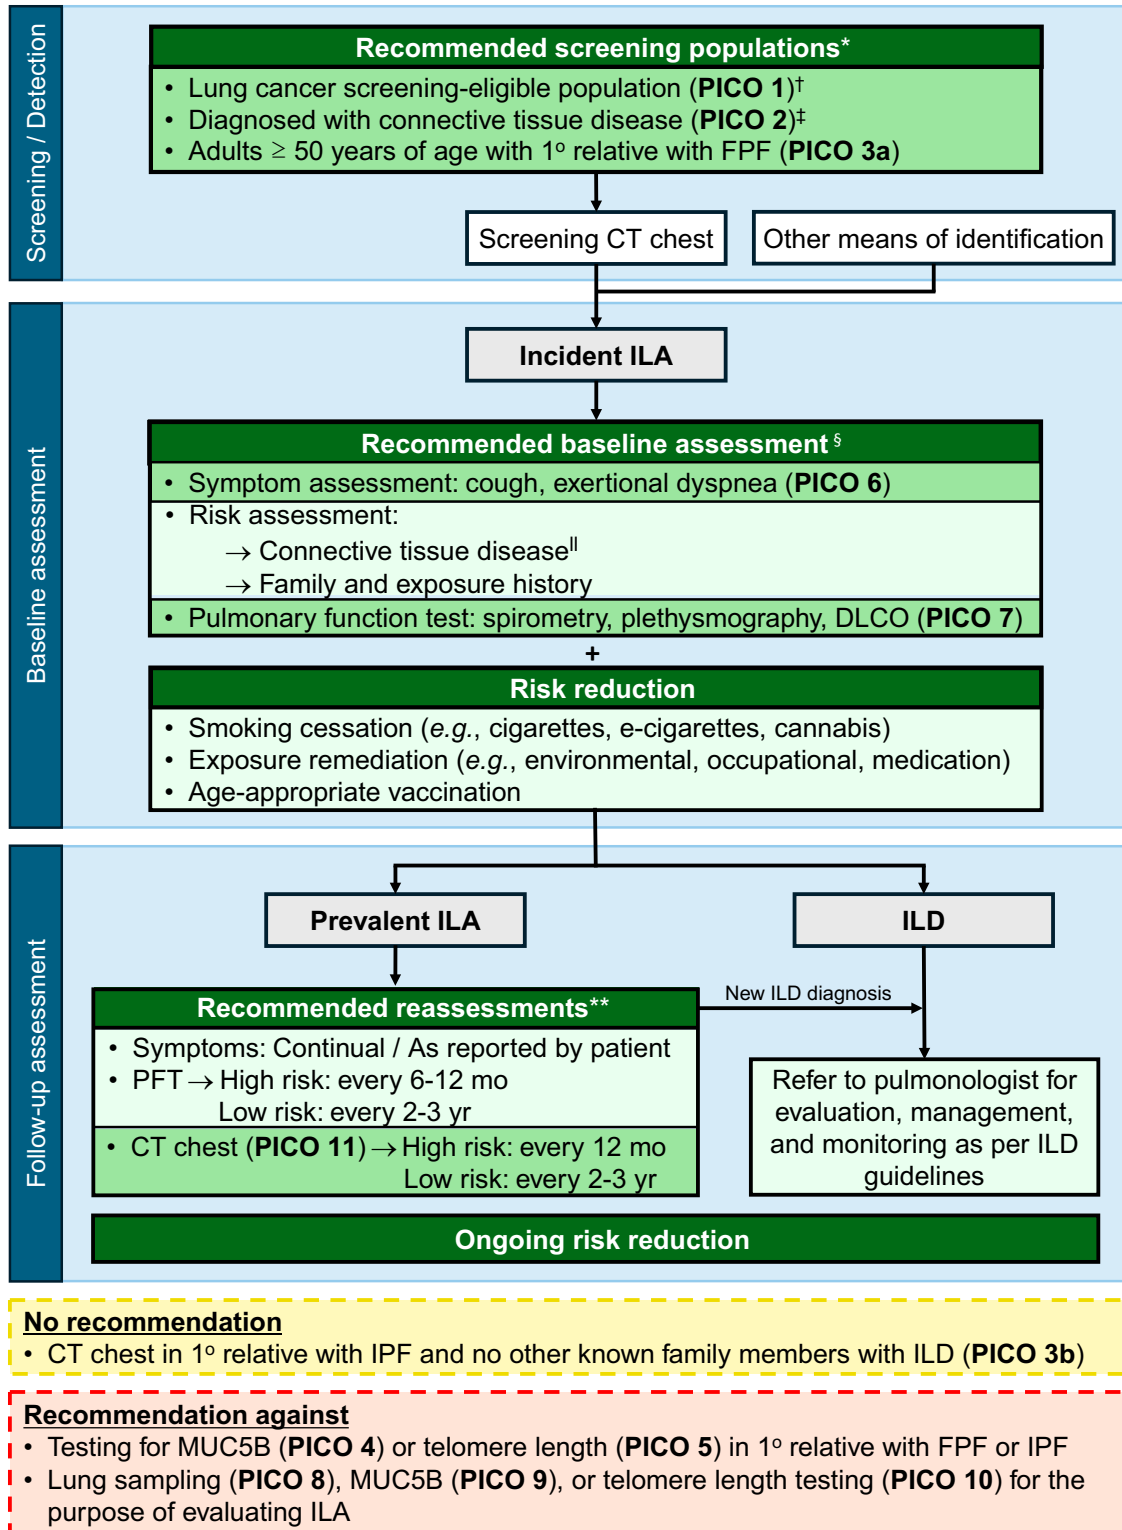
Evaluation and management of interstitial lung abnormality (ILA). Actions shown in darker green boxes indicate recommendations formulated based on prespecified population-intervention-control-outcome (PICO) questions, with the PICO question number shown in parentheses. Actions shown in lighter green boxes indicate additional suggestions that were not the subject of prespecified PICO questions. PICO questions that did not reach consensus are shown in dashed boxes at the bottom of the algorithm in yellow (no recommendation) and red (recommendation against). *Other high-risk populations may be appropriate for screening (e.g., high-risk occupations). [†]Patients at increased risk for lung cancer are recommended to undergo chest computed tomography (CT) screening for lung cancer. We further recommend systematic assessment and documentation of the presence or absence of ILAs/interstitial lung disease (ILD) in smokers who are undergoing lung cancer screening with a
